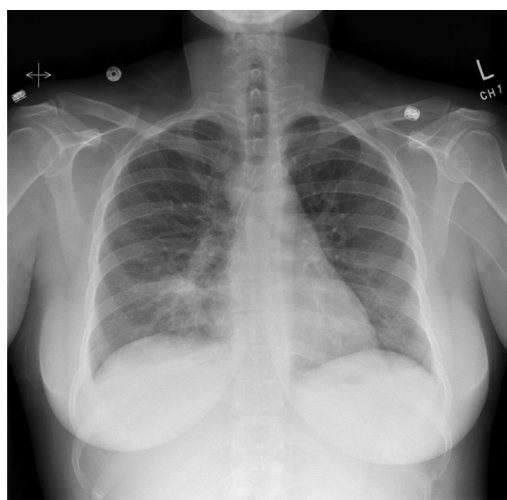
Chest X-ray (PA view) showing right lower lobe consolidation.
